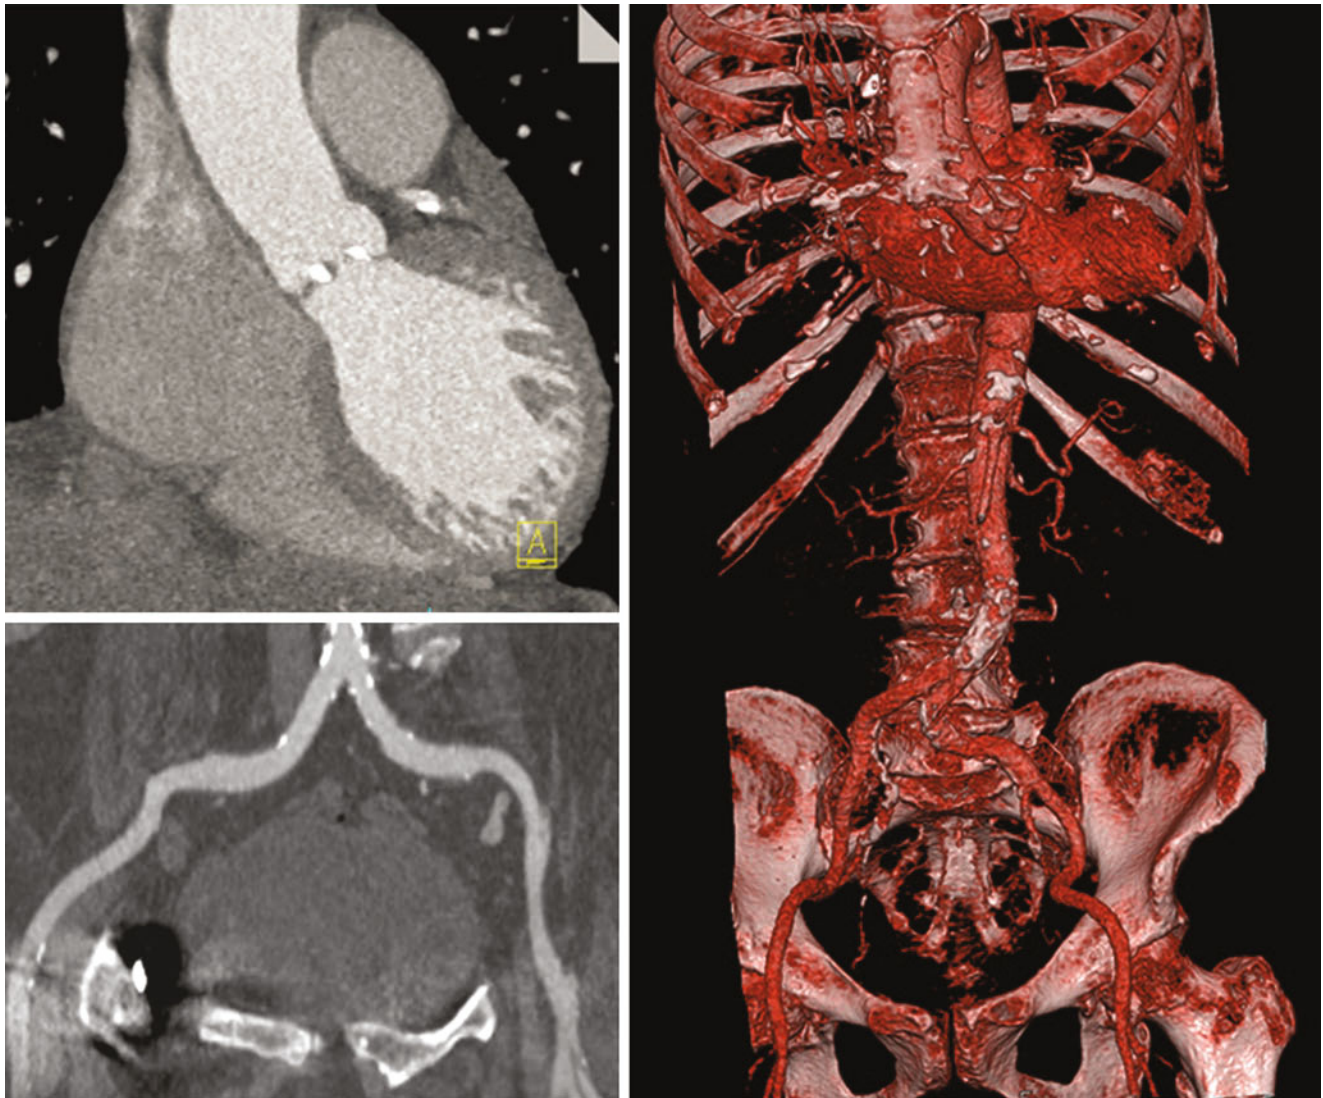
Use of cardiac CT to assess a patient prior to transcatheter aortic valve replacement (TAVR). CT imaging is routinely used in candidates who undergo workup for potential TAVR. With high and isotropic spatial resolution and the ability to generate a large-volume data set within a short time, CT is well suited to support cardiac interventions by providing specific anatomic information. The 3D reconstructions
